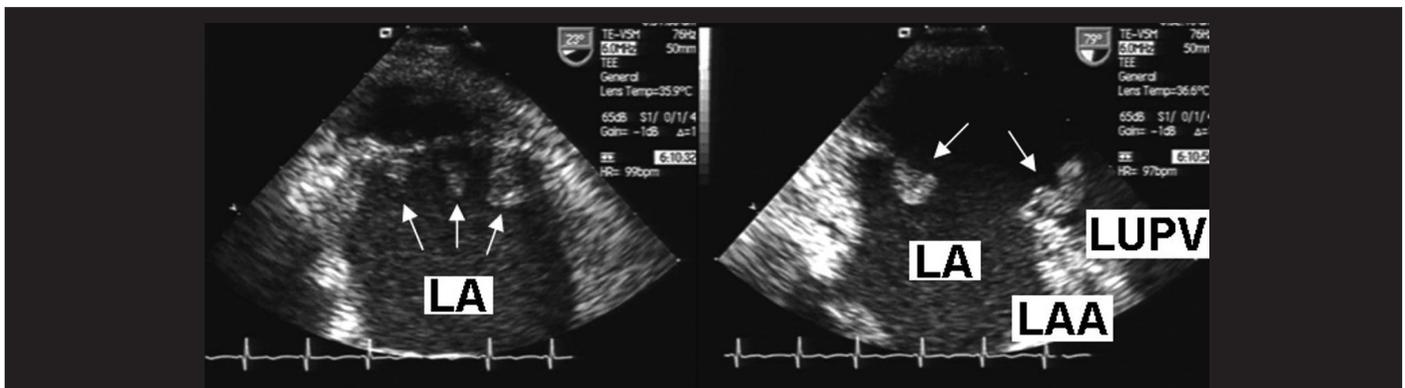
Transesophageal echocardiography: views from the long-axis showing mobile pedunculated left atrial masses attached by narrow necks to the suture line. (Arrows)
